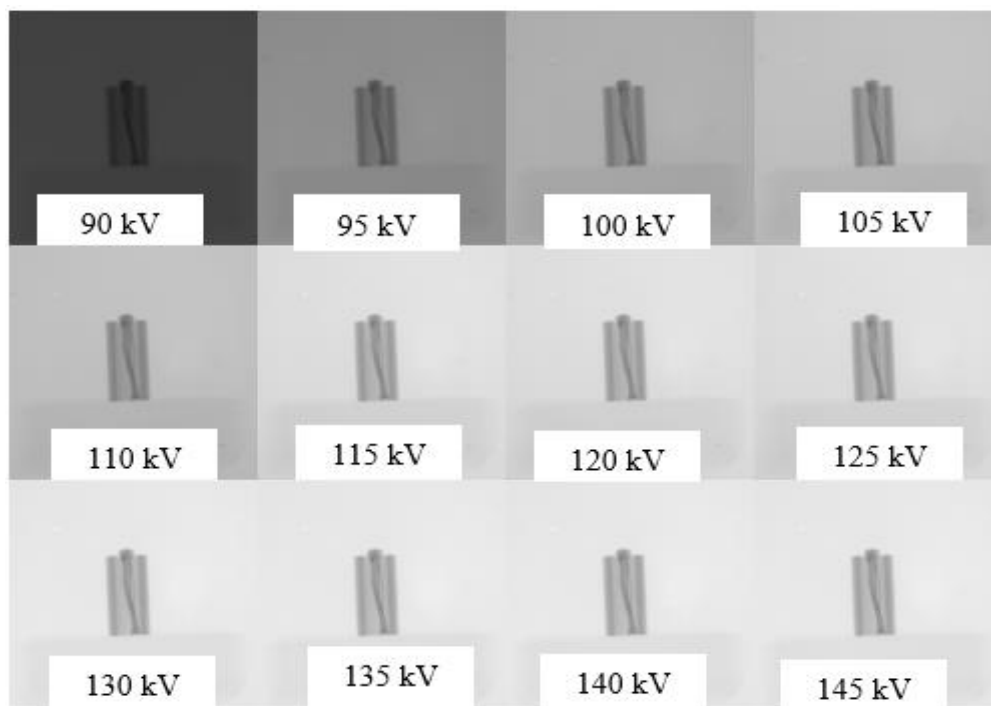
Typical radiographs that were acquired within the X-ray tube voltage range of 90kV-145 kV, X-ray current of 100 μ A, FSD of 65 cm and X-ray exposure time of 1 sec.
